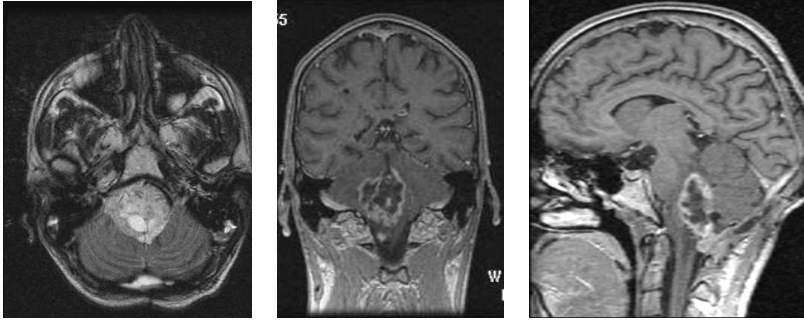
IVth ventricle ependimoma. T1 sequence in contrast MRI.
